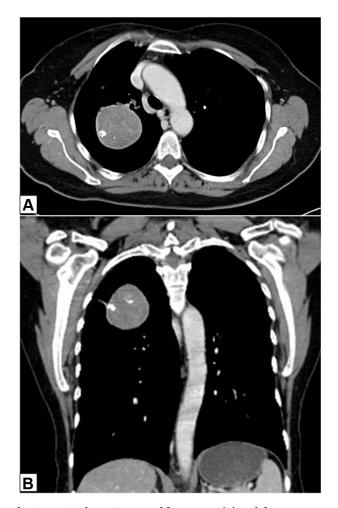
PPSS in a 68-year-old woman. (A) Axial contrastenhanced CT scan of the thorax demonstrating a well defined, heterogeneous mass in the right upper lobe with internal septation, and peripheral thin enhancing rim. (B) Coronal-reconstructed image shows multiple well-defined foci of calcification.
